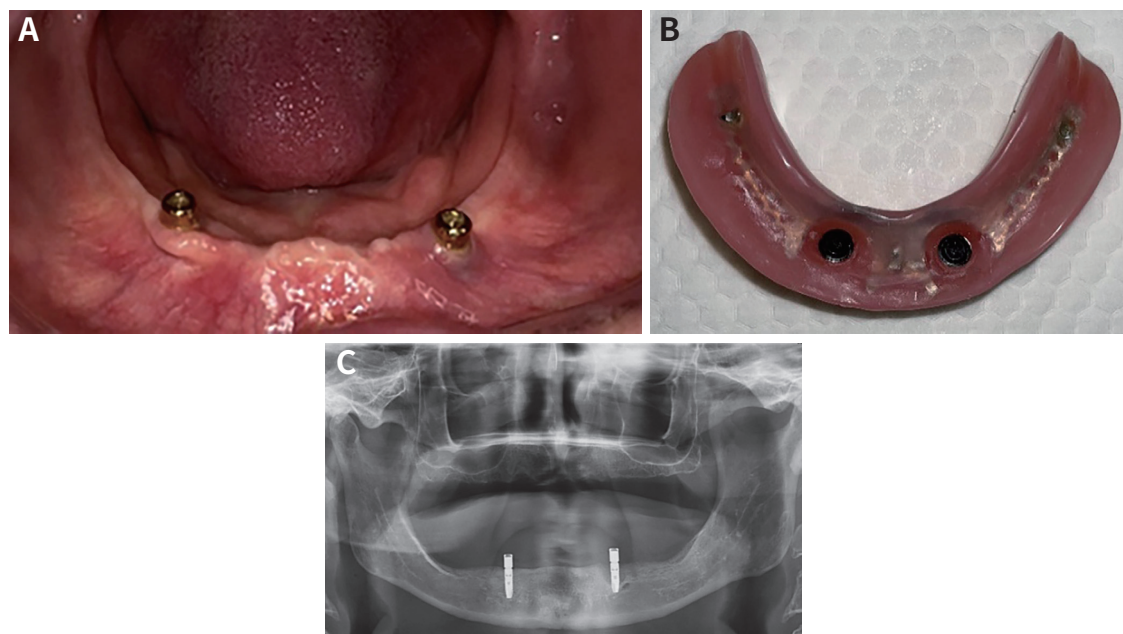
(A) Intraoral view of attachments after 3 years of use, (B) The metal framework was placed in order to prevent fractures that may occur in all dentures, (C) Panoramic radiographic view of two dental implants.
